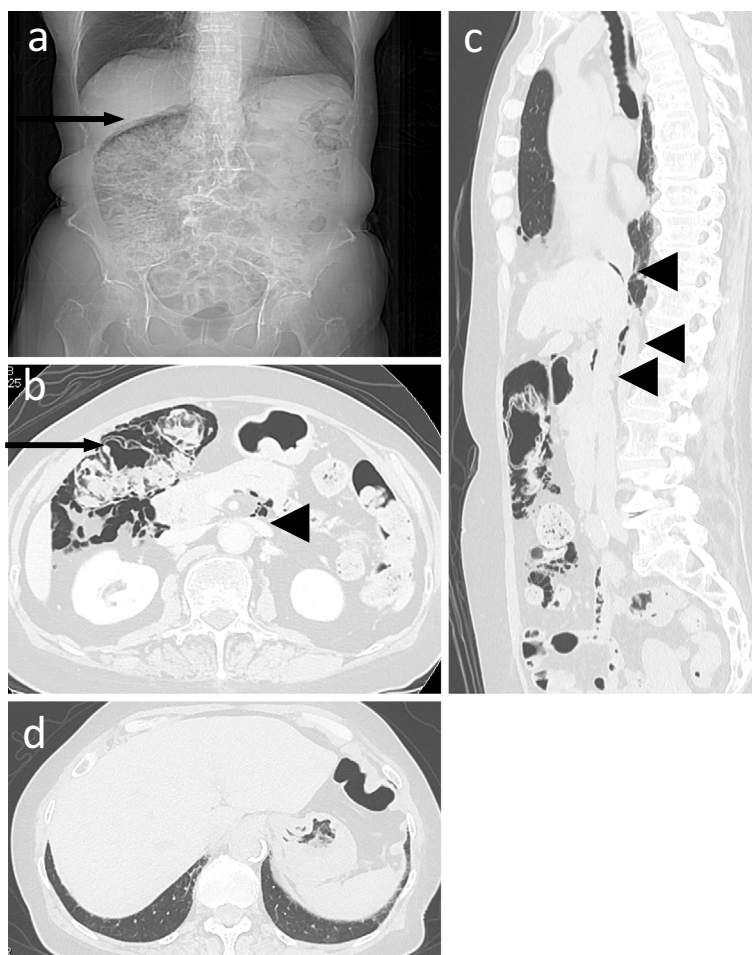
Abdominal X-ray (a) and computed tomography (b, c) findings on the second hospital admission. The accumulation of gas within the intestinal wall (arrow) of the ascending and transverse colon on abdominal X-ray and computed tomography (CT). Free air (arrow heads) in the peritoneal cavity and retroperitoneum was detected. There were no findings suggestive of interstitial pneumonia on chest plain CT (d).
